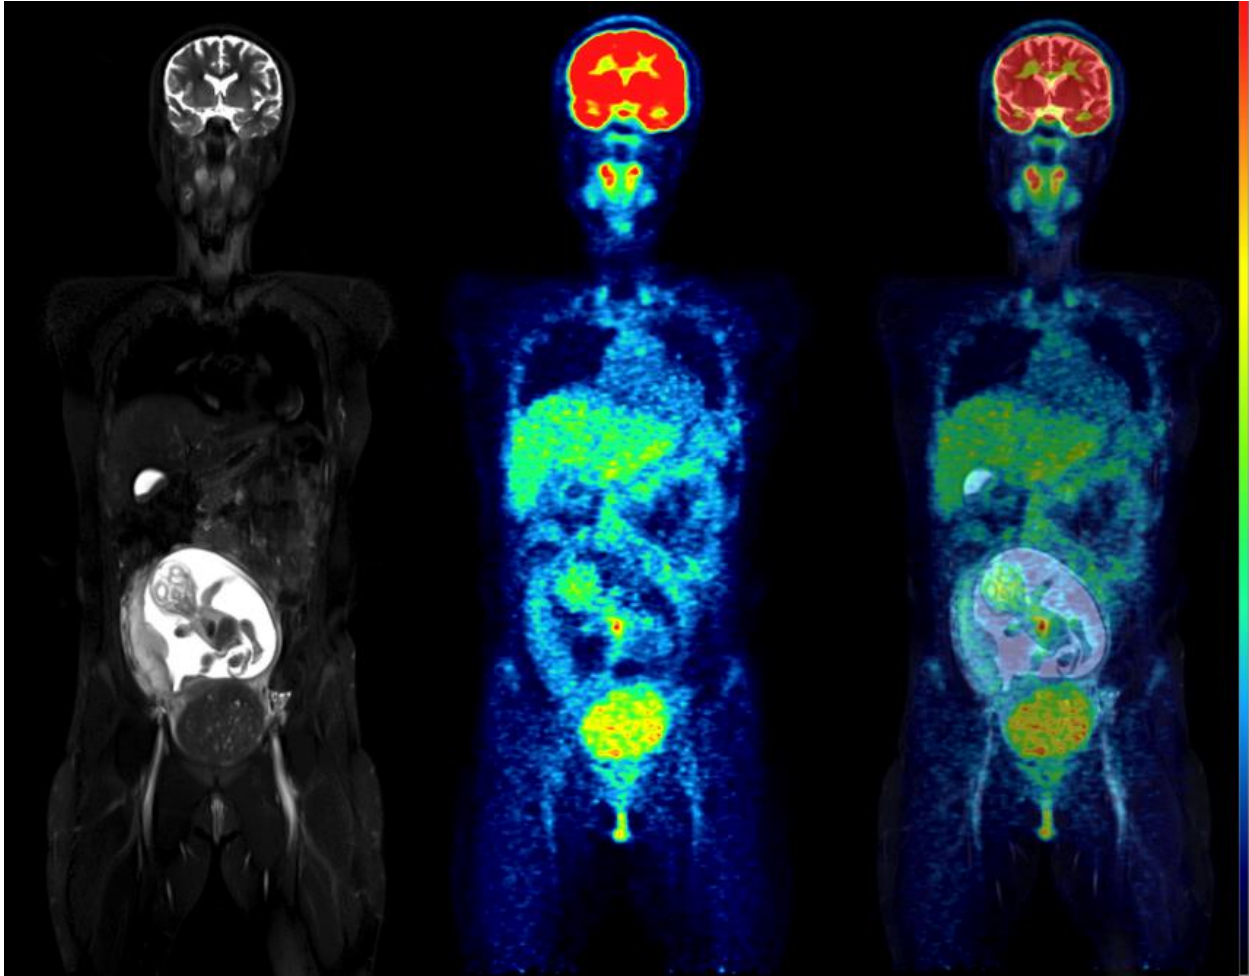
Coronal slices of MRI (left), PET (center), and fused PET/MRI (right) of a woman in the 18th week of pregnancy. Of particular interest is the level of uptake in the fetal organs. While the heart showed high ¹⁸F-FDG uptake, the brain had only a low level of glucose consumption, especially compared with the brain uptake of the mother. This pattern of low glucose consumption has previously been noted even in mature fetuses (4).
